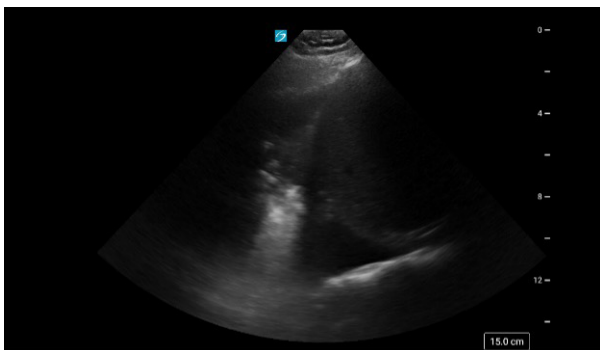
Lung ultrasound score 2
